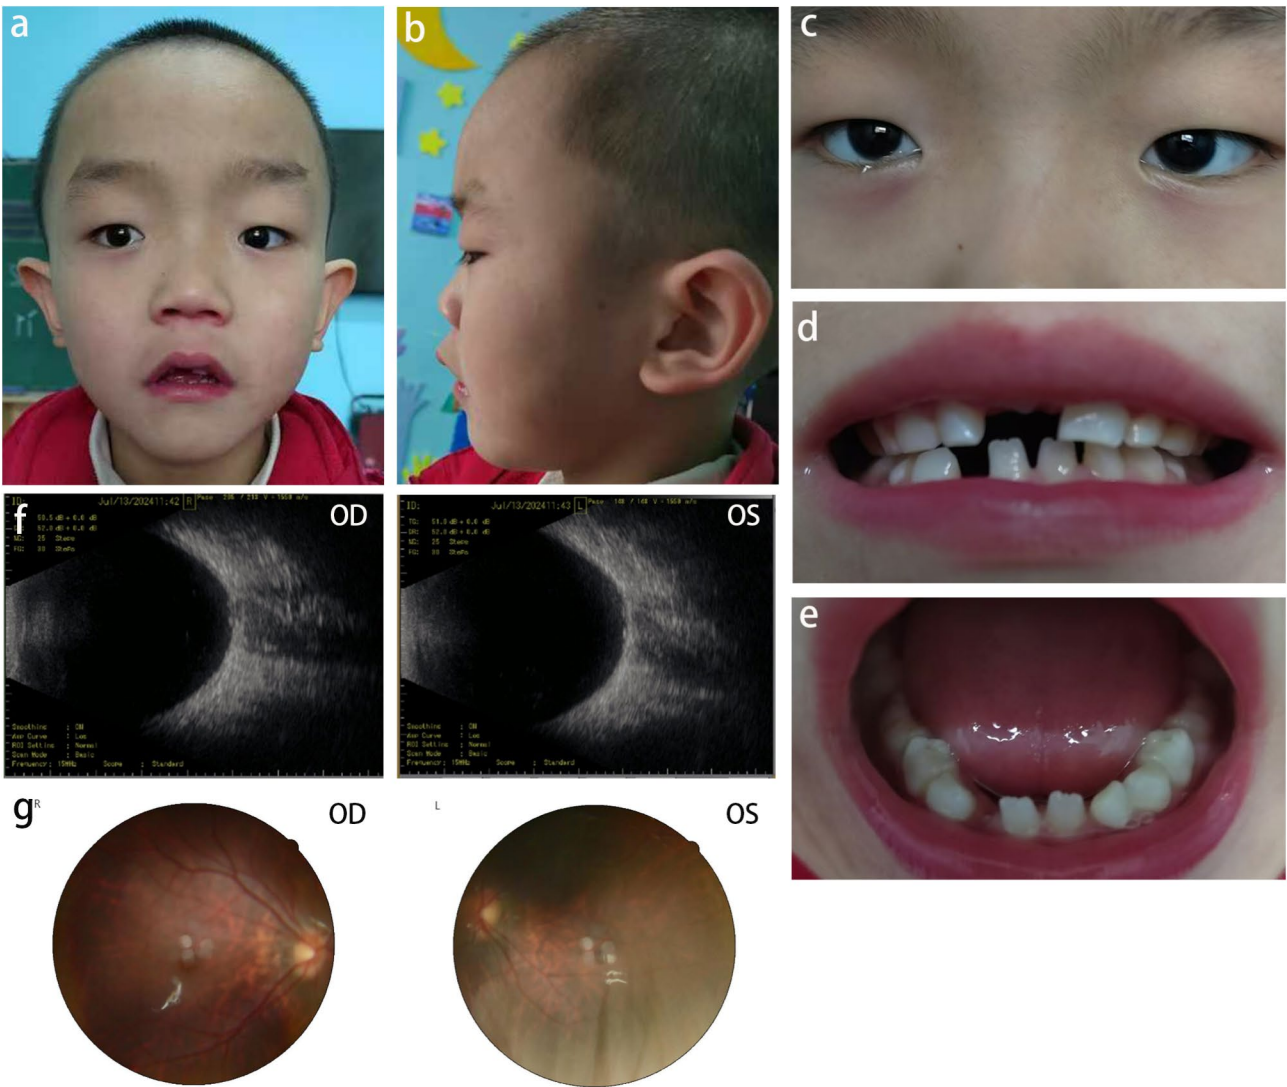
The clinical phenotypes and ophthalmological examinations of the proband’s affected brother (III:3). (a–b) III:3 representative facial dysmorphism of the NHS patients. III:3 had a long and narrow face, and the ears were anteverted, with a bulbous nose. (c) III:3 presents with the phenotype of congenital ptosis in both eyes. (d–e) Representative dental abnormalities of the III:3. Intraoral images demonstrating screwdriver-shaped incisors and mulberry-like molars. (f) B-scan ultrasound of both eyes showing prominent posterior staphyloma. (g) Fundus images of the III:3, with unclear optic atrophy and tigroid fundus
